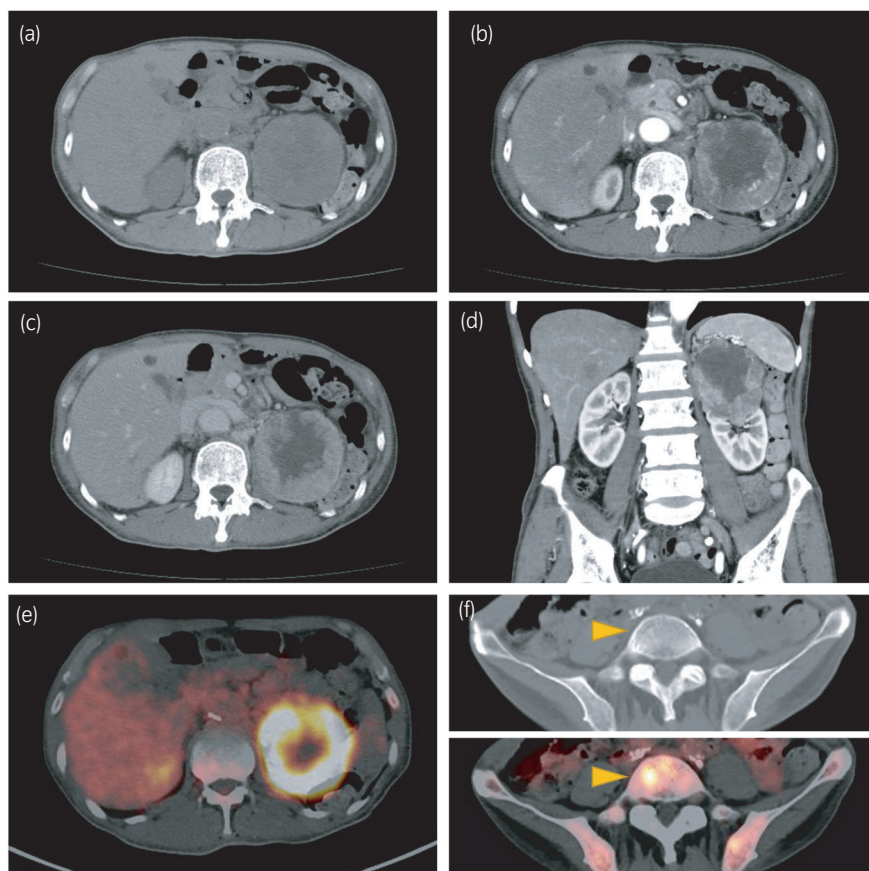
Computed tomography findings of the left renal tumor and osseous lesions. (a) plain CT, (b) arterial phase, (c) venous phase, (d): Sagittal image in arterial phase, (e) FDG-PET image, (f) representative images of osseous lesions in plain CT (upper) and FDG-PET CT (bottom).
